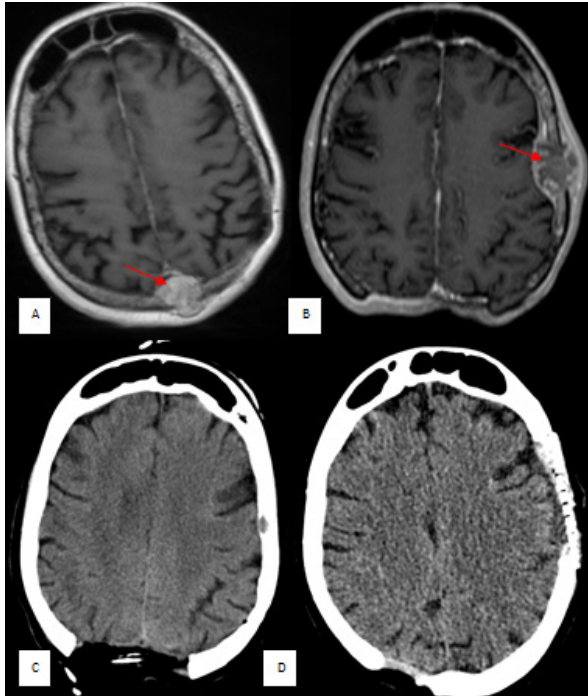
(A, B) Axial postcontrast T1w MRI of the brain showing 2 cm sized midline posterior parietal bone metastasis invading the superior sagittal sinus (A, arrow) and 35x25 mm sized left parietal bone metastasis (B, arrow) involving to the adjacent scalp and dura with epidural extension. Surgical removal of both lesions is seen on axial CT images (C, D)
